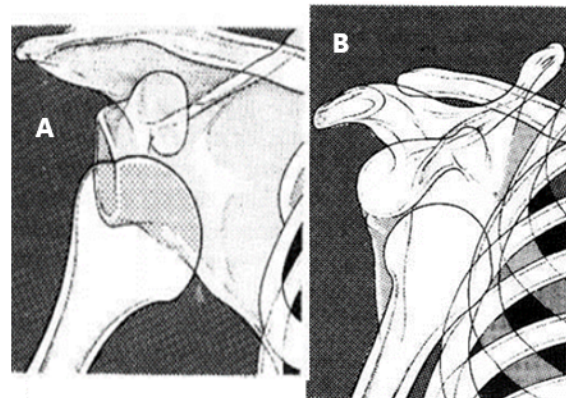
RADIOGRAPHS OF AN ANTERIOR SHOULDER DISLOCATION. A. *always take an AP and B, an oblique view before you try to reduce what might seem to be an ordinary dislocation.* If you do this routinely, you will not miss a rare posterior dislocation. *N.B.* 25% of all acute dislocations are associated with a fracture, most commonly a fracture of the greater tuberosity.
